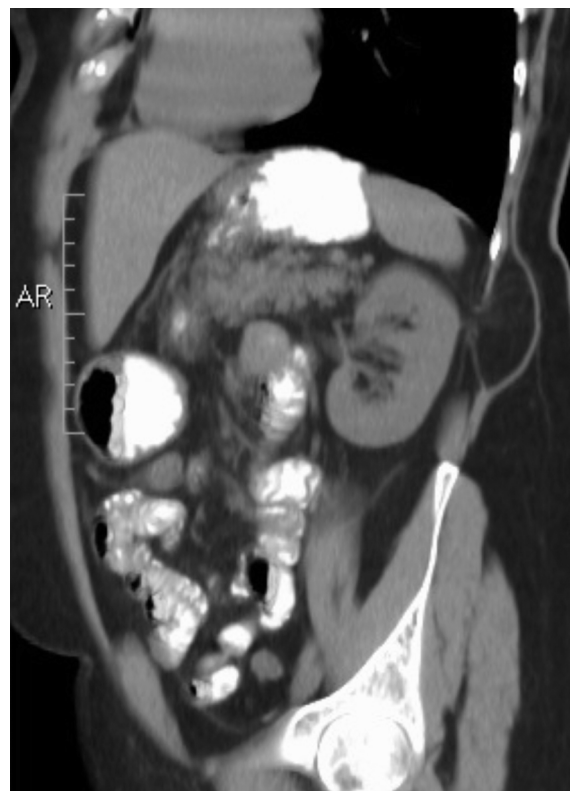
CT scan: sagittal view showing a subfascial oval hypodense formation, directly connected to the abdominal cavity.
